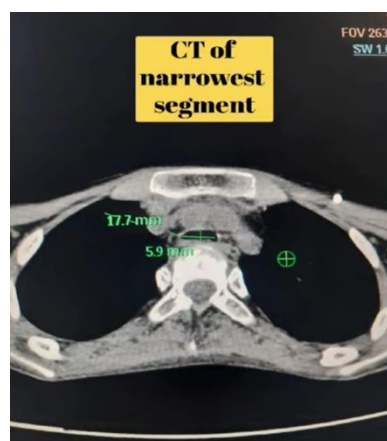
CT showing narrowest section of trachea.
